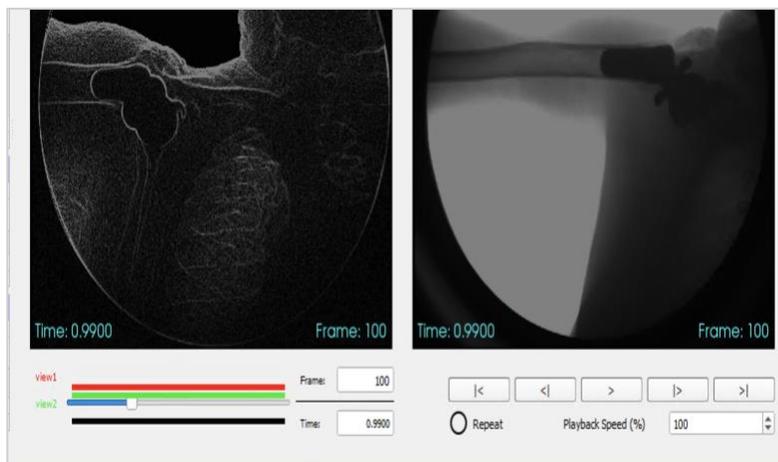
Select frame captured during arm elevation as viewed within X4D of the C-motion suite. Displayed on the right is the original x-ray in the posterior view. The corresponding frame on the left is the processed x-ray in the anterior view, obtained upon selecting the automatic x-ray processing function within the software. Pre-processing is to be implemented with the purpose of improving the resolution of individual elements in the implant/anatomical system.
